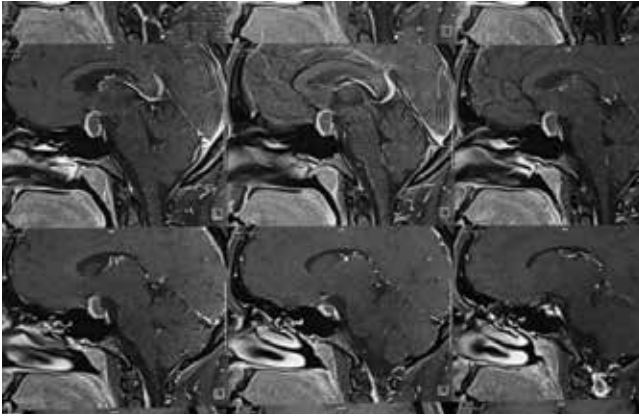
Contrast-enhanced T1-weighted sagittal magnetic resonance (MR) image showing pituitary lesion with peripheral enhancement
